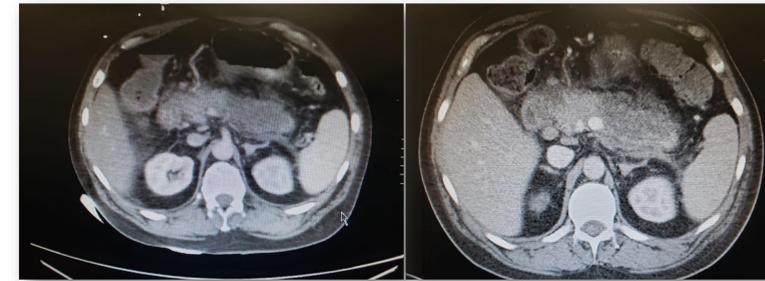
CT scan on day 6 showing persisting and increased inflammation.
